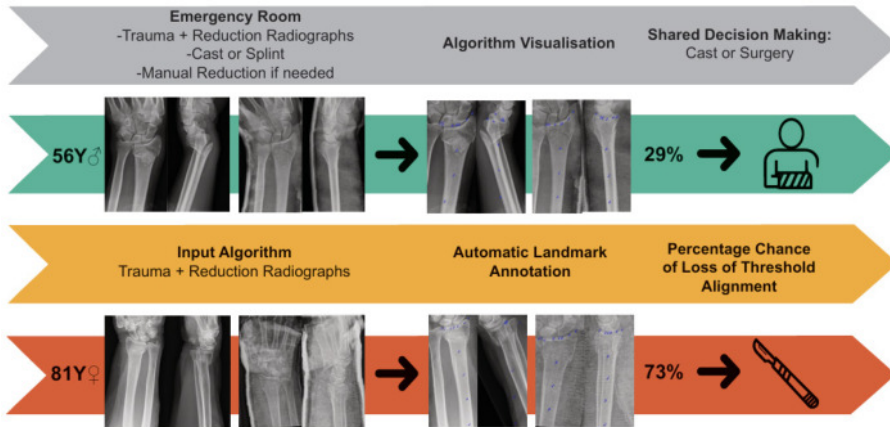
Practical application of the algorithm: patients arrive at the emergency room where radiographs will be made, followed by visualization of the landmarks by the algorithm with a percentage chance of loss of threshold alignment, allowing for shared decision making.
